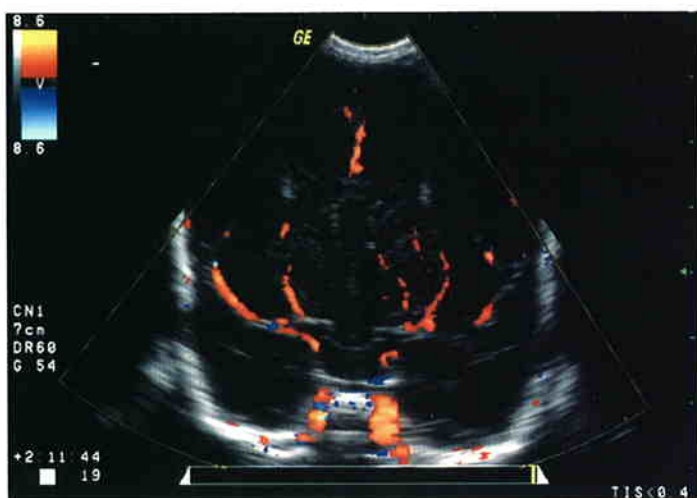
Colour Doppler imaging of the lenticulostriate arteries. (coronal view)
